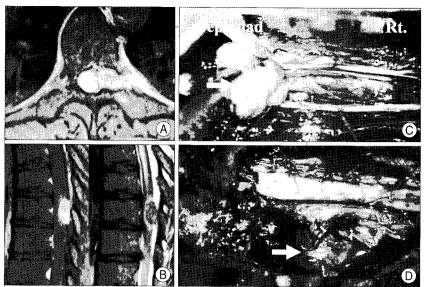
Initial thoracic magnetic resonance images (A and B) showing a well enhanced intradural extramedullary mass and an additional abutting extradural mass. The intradural mass is located in left side of the spinal cord (C). There is also an extradural mass (D).
